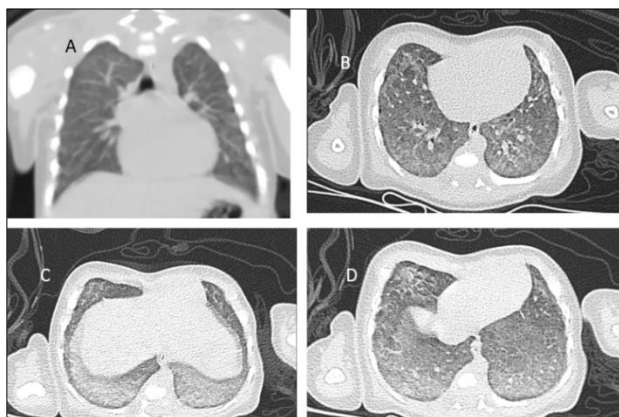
CT chest revealing diffuse ground glass opacities in bilateral lung parenchyma
